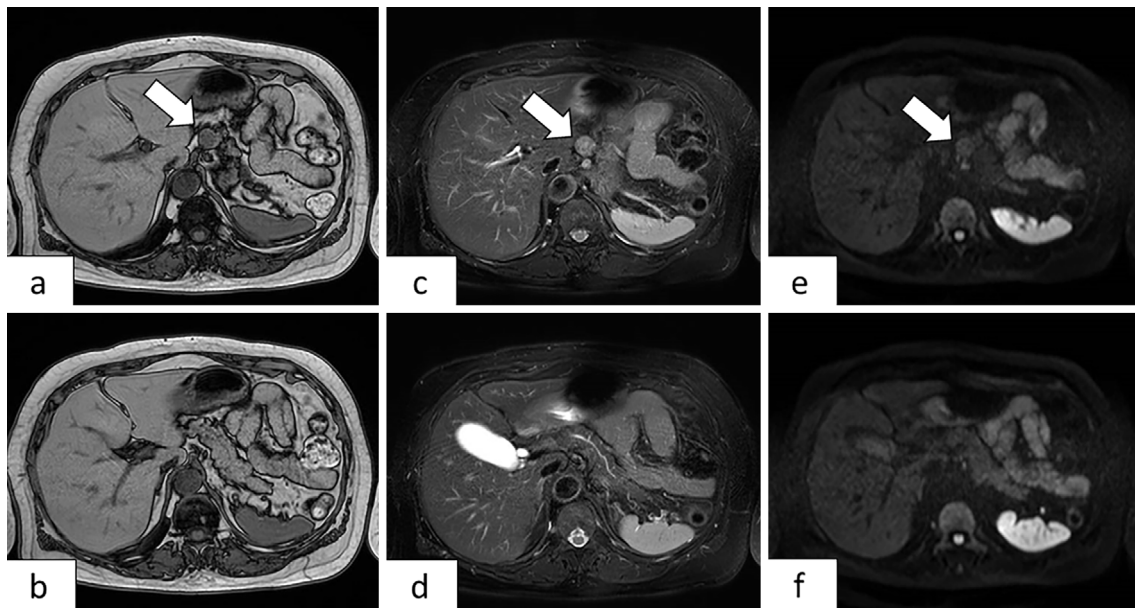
Abdominal MRI findings. A low signal intensity was found with T1-weighted imaging (a, b), high signal intensity with T2-weighted imaging (c, d), and minor diffusional limitation with diffusion-weighted imaging (e, f). The signal of the tumor is clearly different from that of the surrounding pancreatic parenchyma.
